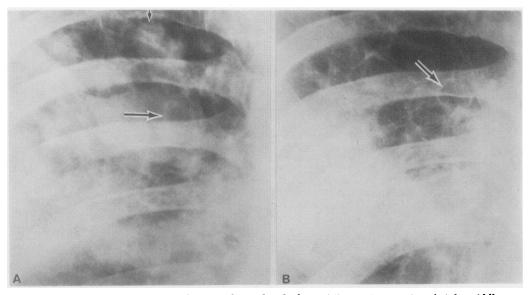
Radiographic appearances of ring and circular shadows: (A) massive opacity of right middle zone towards axilla; ring shadow opposite horizontal arrow and circular shadow opposite vertical arrow; (B) partial clearing of the opacity showing ring shadows; arrow points to a 1.5 cm ring shadow.
